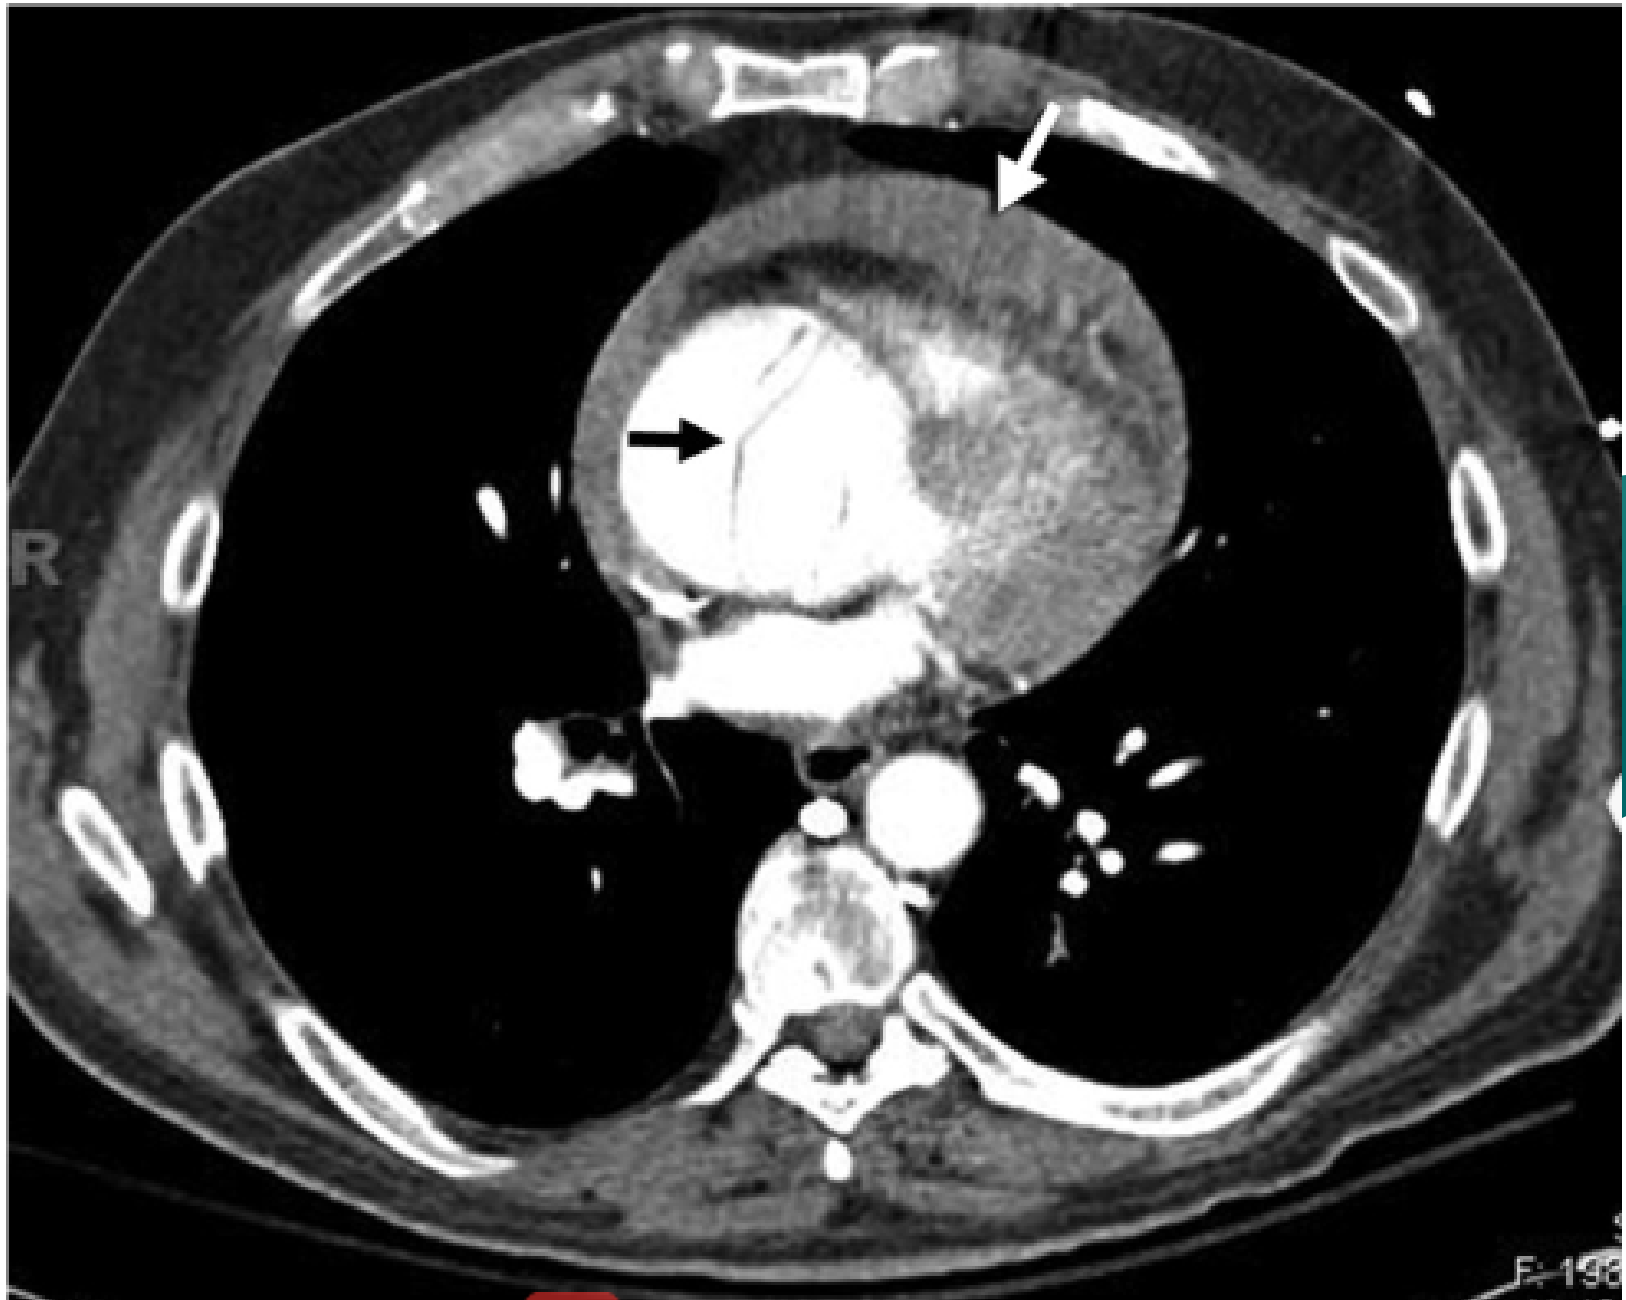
FIGURE e57-14 Contrast-enhanced CT scan of acute type A aortic dissection (black arrow) with associated hemopericardium (white arrow).
